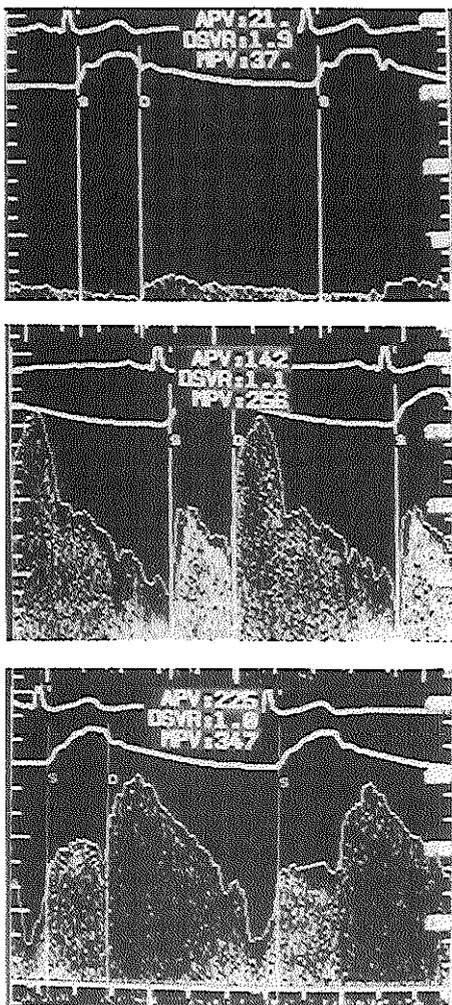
Upper panel: Doppler flow velocity tracing proximal to a 70% cross-sectional area stenosis of the left anterior descending coronary artery (scale, 0–400 cm/sec). Middle panel: when the Doppler probe is advanced into the stenosis, the flow velocity shows a large increase of the average peak velocity and especially of the systolic flow velocity component (decrease of the diastolic/systolic velocity ratio from 1.9 to 1.1; scale, 0–400 cm/sec). Lower panel: a further increase is observed after contrast-induced hyperemia. Note the perfectly defined Doppler envelope despite the presence of flow velocities of 3.5 m/sec (scale, 0–480 cm/sec). APV = time-averaged peak flow velocity (cm/sec); DSVR = ratio of the time-averaged diastolic and systolic flow velocity components; MPV: maximal peak velocity (cm/sec). All these measurements were automatically performed after spectral analysis of the Doppler signal (FlotMap, Cardiometrics).
